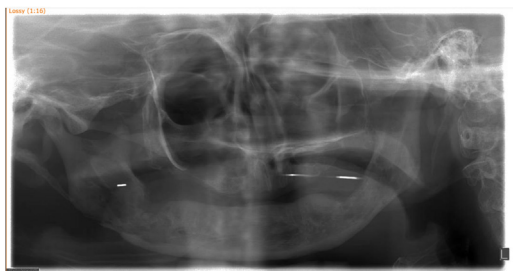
Panoramic radiograph after 3 months of pentoxifylline and tocopherol showing evidence of bone formation.
